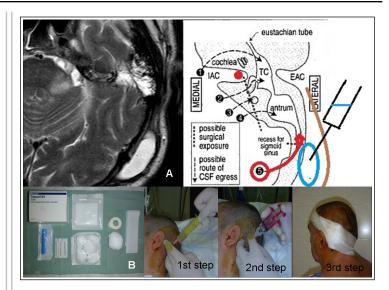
Definitive treatment of lateral variant of CSFL with epidural CSF collection. A: MRI and scheme of lateral variant of CSFL with epidural CSF collection (pseudomeningocoele) and its management. B: Technique of its definitive management with materials used, 1st step: total aspiration of pseudomeningocele, C: 2nd step: epidural instilation of tissue glue, D: 3rd step: compressional bandage.
